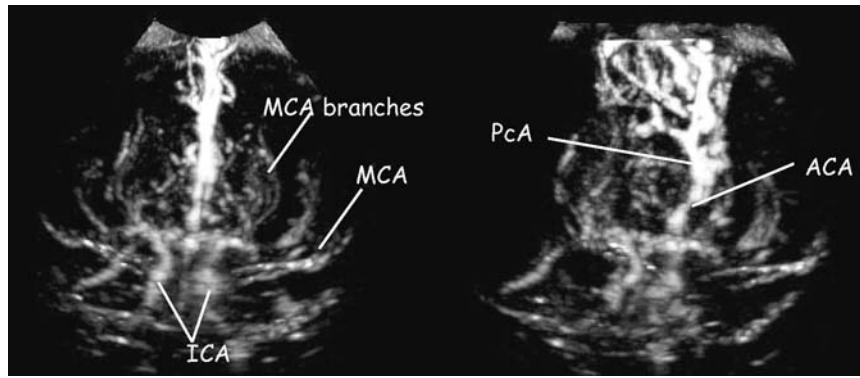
Three-dimensional power Doppler image of fetal brain circulation. (Left) View from the front. Bilateral internal carotid arteries (ICA) and middle cerebral arteries (MCA) and branches of MCA are demonstrated. (Right) Oblique view. Anterior cerebral artery (ACA) and pericallosal artery (PcA) are demonstrated.
